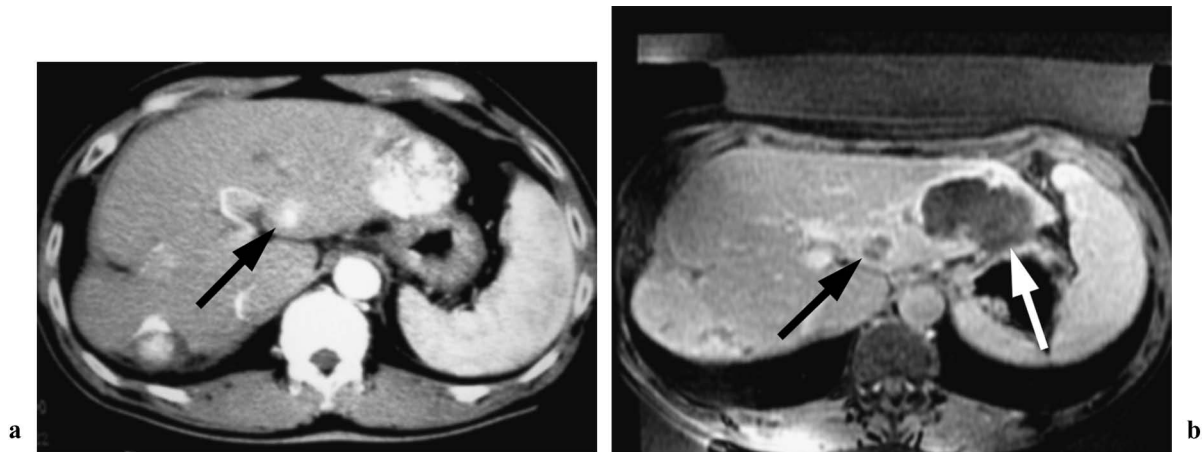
Hepatocellular carcinoma. a: Enhanced computed tomographic (CT) image before focused ultrasound ablation (FUS). A small enhancing nodule 12 mm in diameter (arrow) can be seen on the arterial phase enhanced CT image before FUS. b: Gadolinium-enhanced T_1 -weighted spoiled gradient recalled-echo MR images (repetition time/echo time [TR/TE], 6.4/2.8 s; flip angle [FA], 10°) after FUS. After FUS, gadolinium-enhanced T_1 -weighted magnetic resonance (MR) image shows no enhancement of the entire lesion, indicating complete necrosis (black arrow). The large hepatocellular carcinoma (diameter, 5 cm) with iodized oil, seen in the lateral segment (white arrow), is the lesion previously treated with transcatheter arterial embolization with iodized oil that was not treated this time because it showed no sign of local recurrence.
